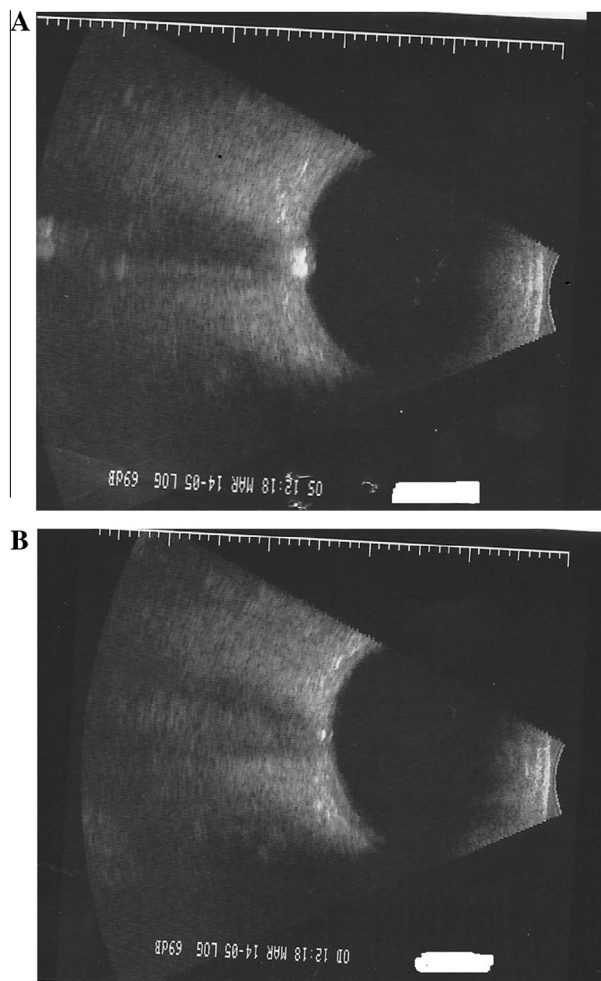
(A) A healthy, 15-year-old patient presented to the emergency room with a sudden lower left visual field loss that was diagnosed as left anterior ischemic optic neuropathy. Clinical examination showed optic disc drusen which was confirmed with ultrasonography. The hyperechogenic artifact is seen clearly in B mode ultrasound. (B) There are no drusen on the right side.
